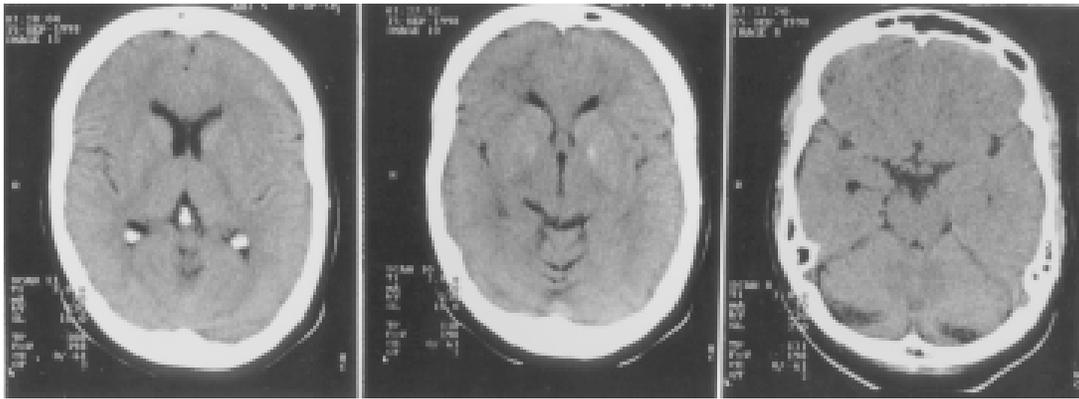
Computed tomography scan showing what was considered slight cerebellar atrophy, predominantly in the vermis.
